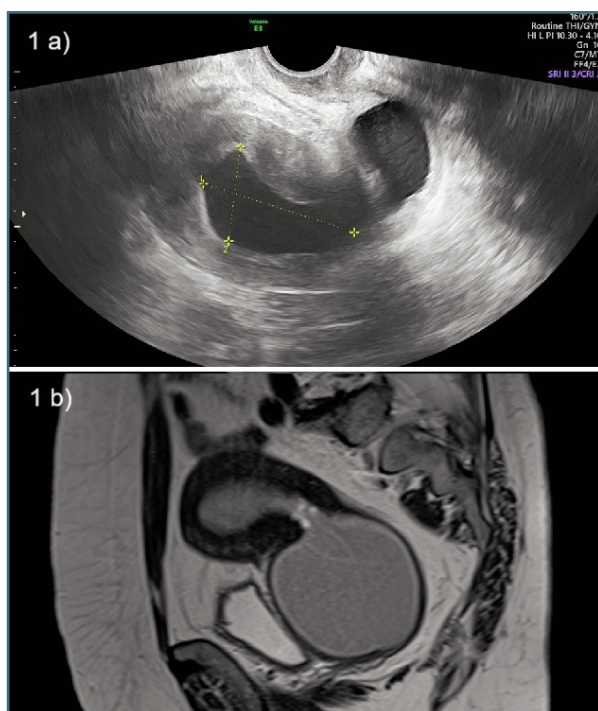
Transvaginal ultrasound (a) and parasagittal MRI (b) showing enlarged postmenopausal uterus with moderate cavity distension and severe distended cervical canal. Both structures are filled with hematic content. Maximum diameter of the uterine cavity – 32 mm; maximum diameter of the endocervical canal – 71 mm. No signs of focal lesions nor neof ormation masses were recognized. Lesions probably secondary to upper vaginal stenosis.
